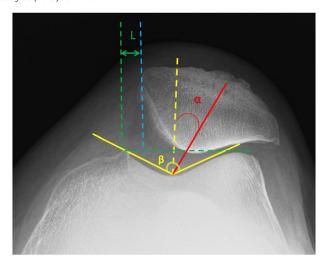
Radiographic measurements of patella femoral joint. Bisect line (Dashed yellow line) of the sulcus angle (β) established a zero reference. A second line extending from the vertex of the sulcus angle to the vertex of the patellar facets forms the patellar congruence angle (α). The length between a line from the highest point of the medial condyle (dashed green line) which is perpendicular to a line connected to the highest points of the lateral and medial condyles and a parallel line connected to the medial border of the patella (dashed blue line) is the lateral patellar displacement (L).
